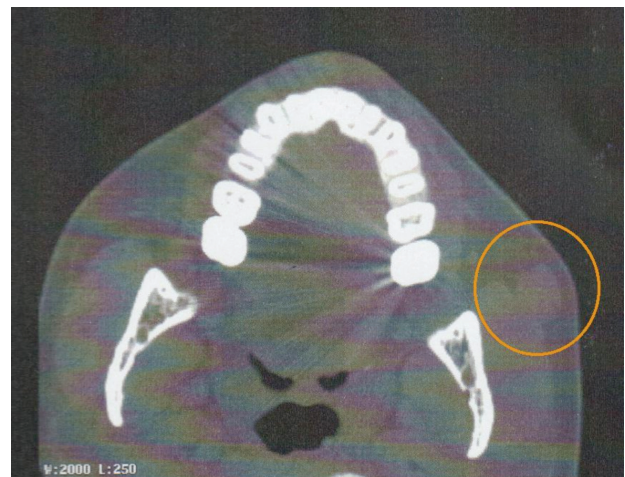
2D Computed tomography, in the axial aspect. Nodule measuring 1.4 x 1.1 cm, located superficially to the masseter.
